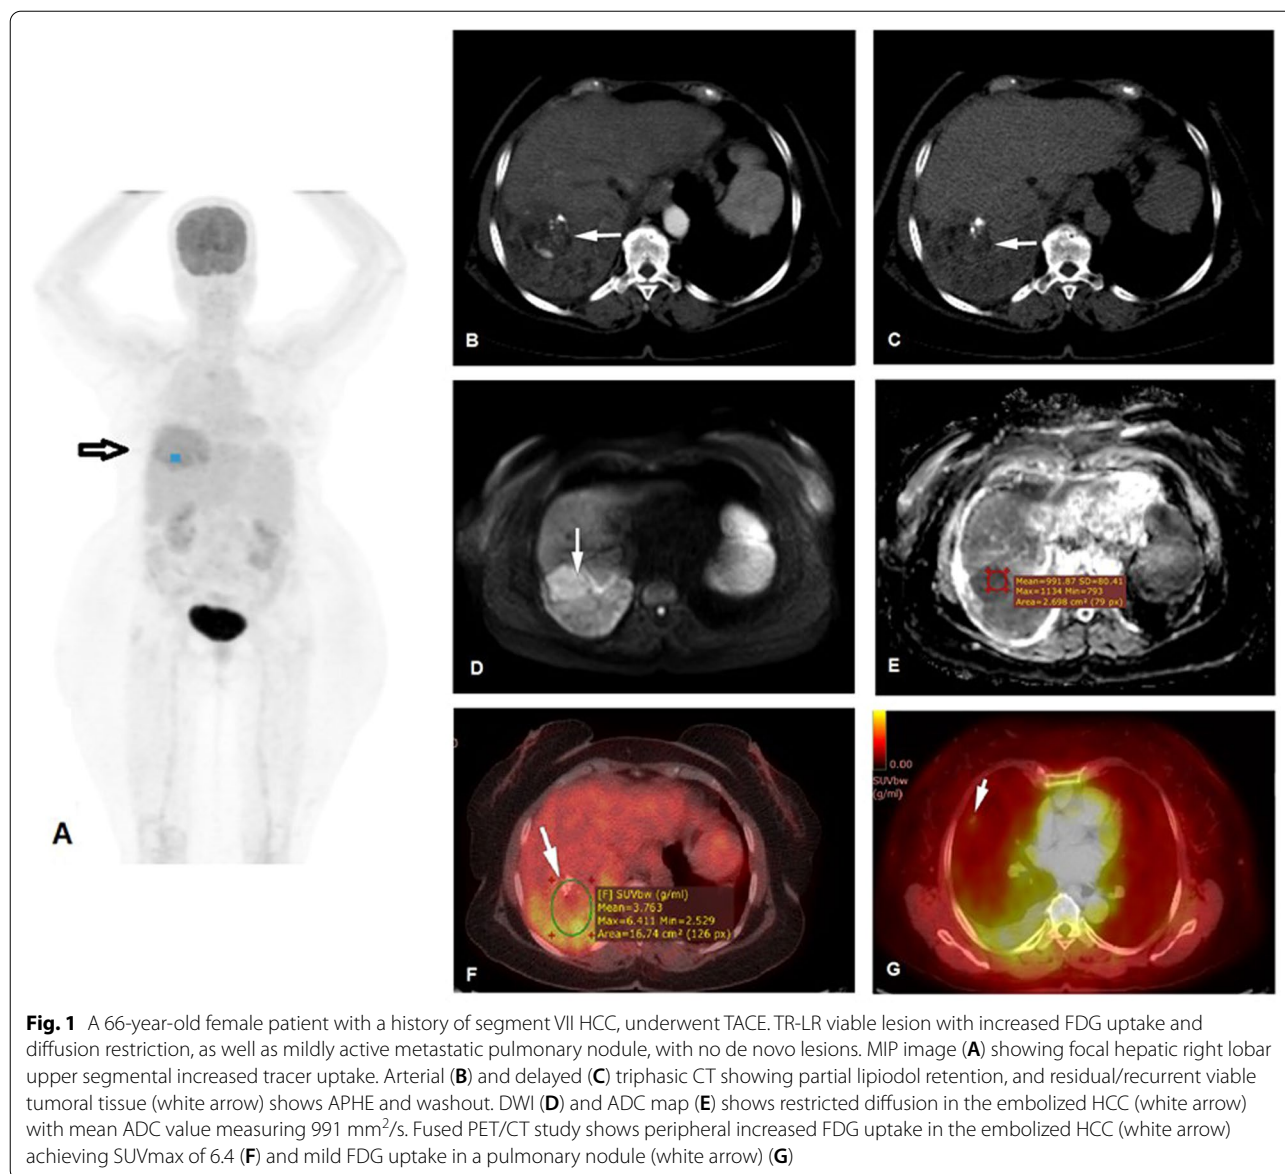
A 66-year-old female patient with a history of segment VII HCC, underwent TACE. TR-LR viable lesion with increased FDG uptake and diffusion restriction, as well as mildly active metastatic pulmonary nodule, with no de novo lesions. MIP image (A) showing focal hepatic right lobar upper segmental increased tracer uptake. Arterial (B) and delayed (C) triphasic CT showing partial lipiodol retention, and residual/recurrent viable tumoral tissue (white arrow) shows APHE and washout. DWI (D) and ADC map (E) shows restricted diffusion in the embolized HCC (white arrow) with mean ADC value measuring 991 mm²/s. Fused PET/CT study shows peripheral increased FDG uptake in the embolized HCC (white arrow) achieving SUVmax of 6.4 (F) and mild FDG uptake in a pulmonary nodule (white arrow) (G)
